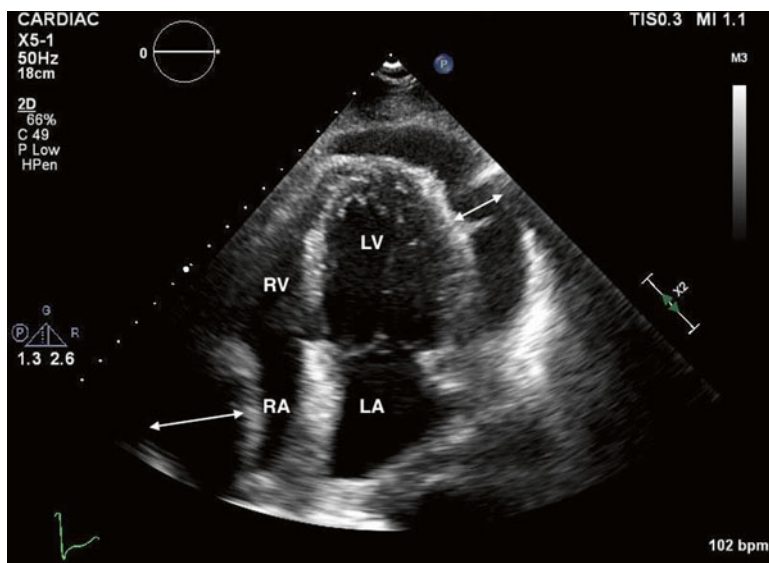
Apical four-chamber view. Near circumferential pericardial effusion (*arrows*), with mass effect on the right atrium (RA) and impaired right atrial filling, i.e., tamponade physiology. Note leftward deviation of the interatrial septum. Thickening of the epicardial surface of the left ventricle, with adherent debris within the pericardial fluid, suggestive of an inflammatory/reactive process. Left ventricle (LV). Right ventricle (RV). Left atrium (LA)
